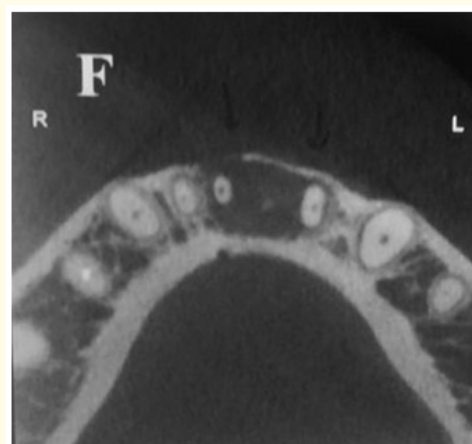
Specific CBCT slice (transaxial), radiolucid image in element 31 apical region.
